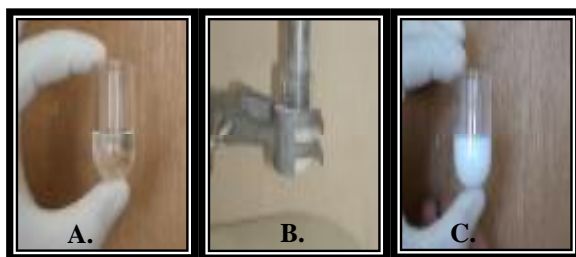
Nano-fillers were well dispersed in the monomer by ultrasonication as shown in A: before, B: during and C: after sonication.
